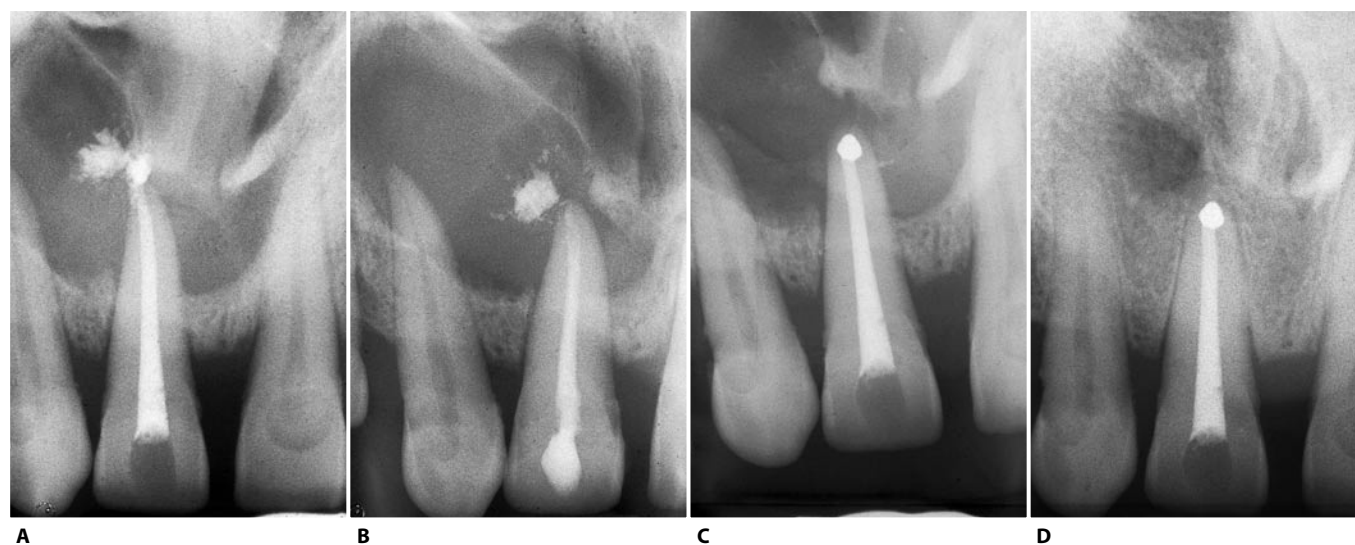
A. Preoperative radiograph of the maxillary central incisor, which has been previously treated endodontically. A large, probably cystic lesion, possibly sustained by the irritant material beyond the apex, is present. B. Postoperative radiograph after nonsurgical retreatment. C. Postoperative radiograph following apicoectomy with retrofilling, performed because of persistent symptoms. In the course of the procedure, performed only to improve the apical seal and remove the irritant material, the cystic wall has been *intentionally* left in place, so as not to compromise the vitality of the adjacent tooth. D. Four years later. The vitality of the cuspid has been preserved. The radiolucency between the two apices does not indicate treatment failure, but rather represents healing with an *apical scar*, a typical outcome of the treatment, nonsurgical or surgical, of large lesions.
